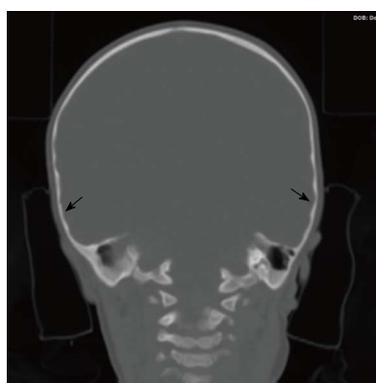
Coronal computed tomography image of the brain demonstrating a local thumb printing/ beaten copper appearance (straight arrows) of the inner cortex in the region of bilateral squamosal fusion.
